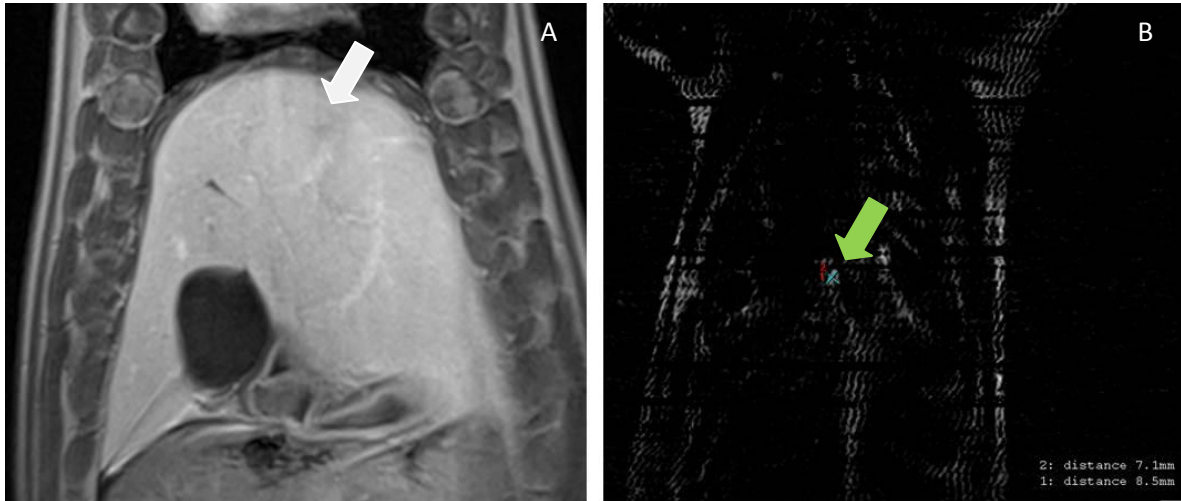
A: MR image (VIBE) used for treatment planning in the liver (white arrow) B: Post-ablation MRI (subtraction of LAVA images before and after ablation), showing a very small ablated area near the diaphragm (green arrow); during necropsy, no ablated area was observed.
